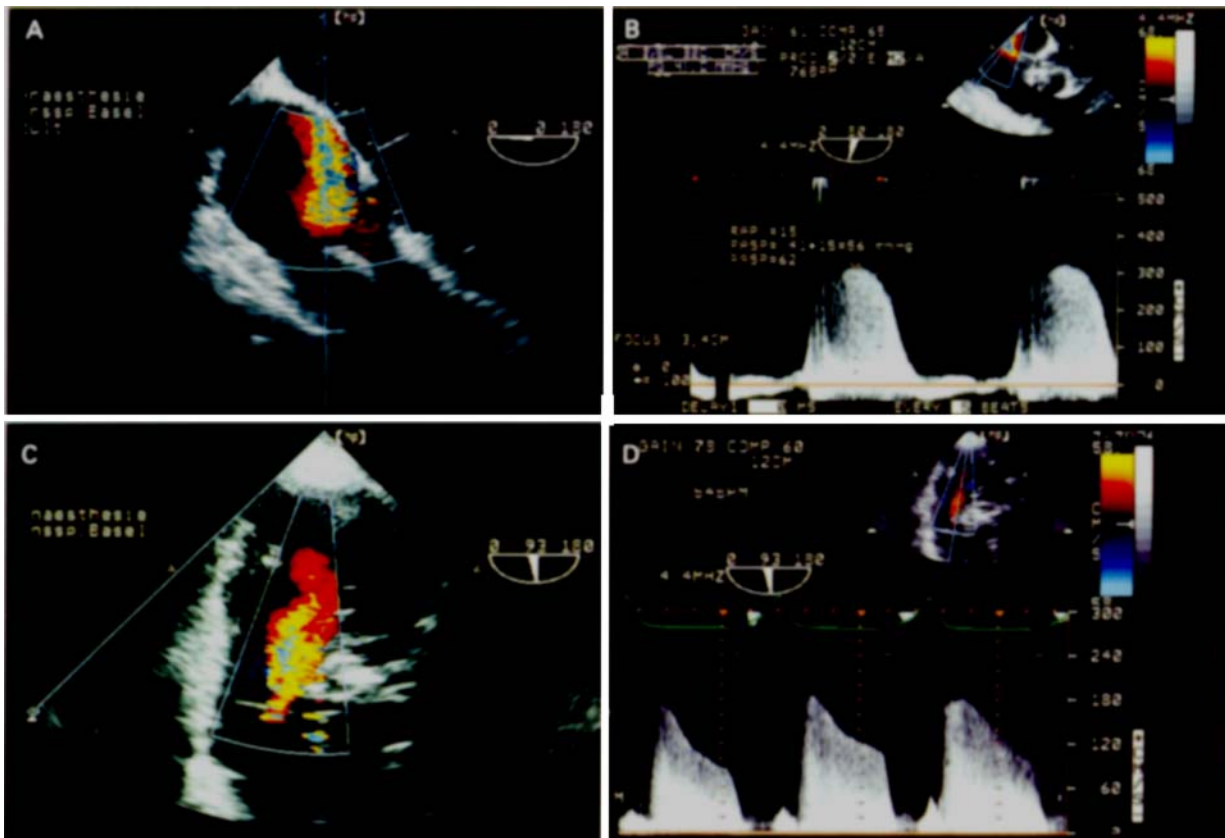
Measurements of the pulmonary pressures. (A) Moderate tricuspid regurgitation detected by colour Doppler, with (B) recording of the tricuspid regurgitation velocity by continuous wave Doppler. (C) Pulmonary regurgitation detected by colour Doppler, with (D) recording of the pulmonary regurgitation velocity by continuous wave Doppler.
